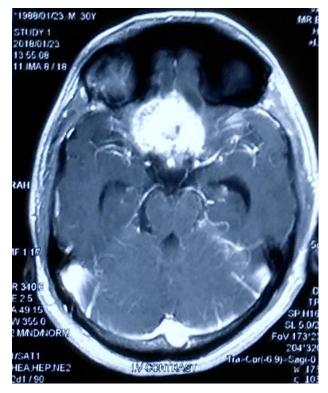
MRI of brain with contrast
